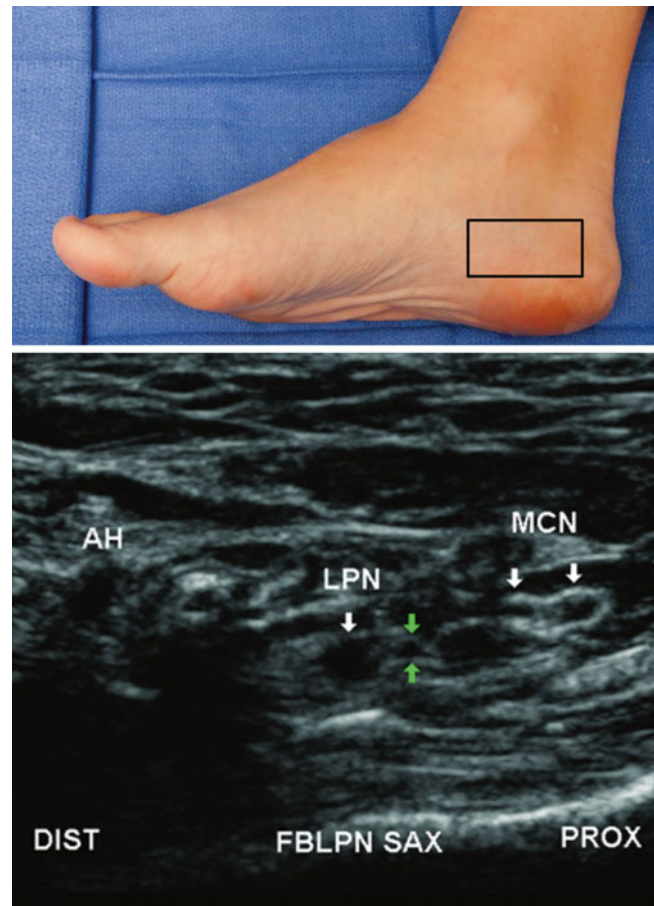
Short-axis sonographic view of the inferior calcaneal nerve. *LPN* lateral plantar nerve; *MCN* medial calcaneal nerve, *green arrows* ICN, *AH* abductor hallucis muscle; bony acoustic margin at the bottom, calcaneus. The ICN lies just posterior to the much larger LPN and is vertical at this level. The two visible branches of the MCN should not be confused with the ICN. The MCN travels obliquely posteriorly and superficially. The QP is just becoming visible between the ICN and the calcaneus (From Presley et al. [5]. Reprinted with permission from the American Institute of Ultrasound in Medicine)
